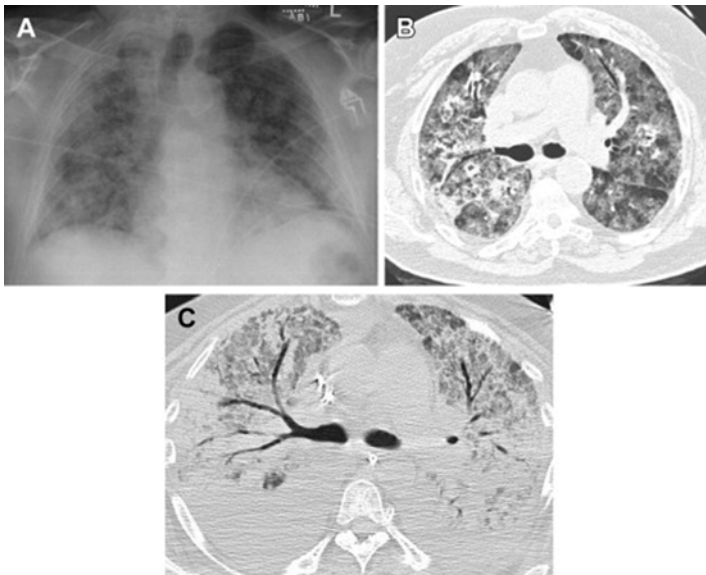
Acute respiratory distress syndrome (ARDS). (a) AP chest radiograph shows low lung volumes and diffuse bilateral pulmonary opacities. (b) Axial CT image in the same patient shows ground-glass and consolidative opacities without pleural effusions. (c) Axial CT image from another patient shows dense bilateral consolidation with air bronchograms and diffuse ground-glass opacity (Reprinted from Bentz and Primack [11], with permission from Elsevier)
